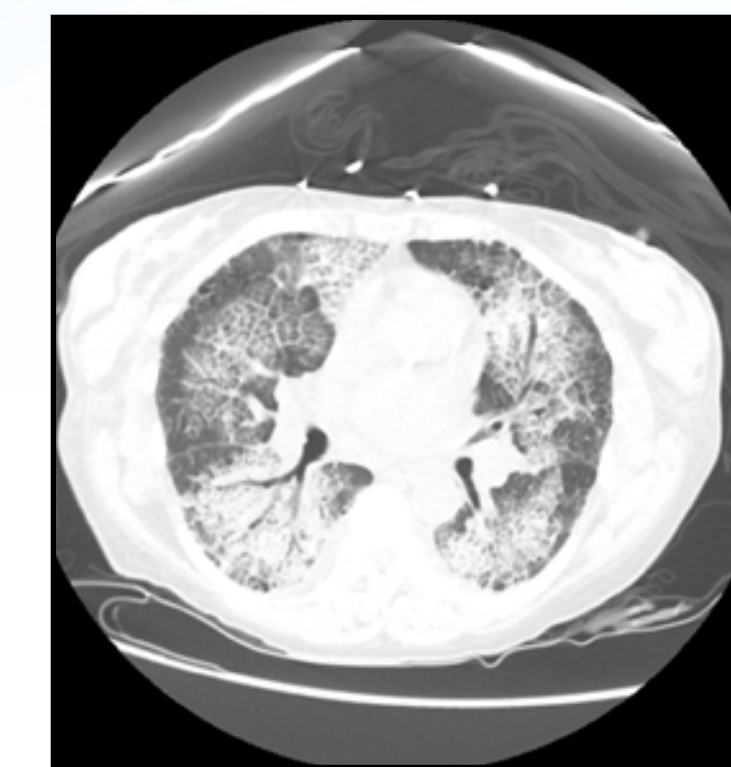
CT of the chest from second admission demonstrating alveolar groundglass opacities and air bronchograms.
